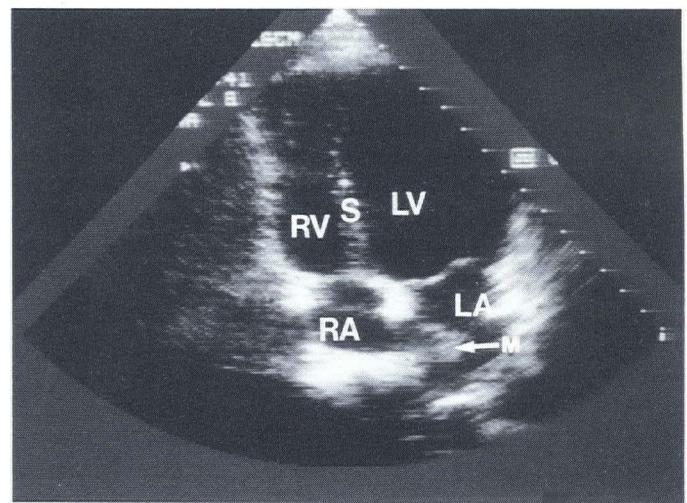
(Case 1)—Two-dimensional echocardiogram demonstrating the mass attached to the interatrial septum (arrow). (M = mass, LA = left atrium, LV = left ventricle, RA = right atrium, RV = right ventricle, S = intraventricular septum.)
